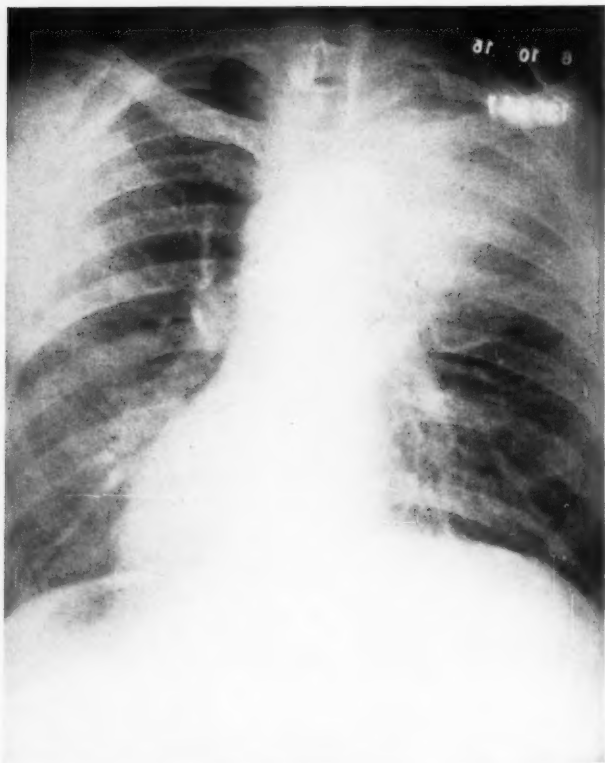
Case 130341. Actinomycosis. Clinical symptoms resembling tuberculosis. Sulphur bodies in sputum. Penetration of chest wall. x-Ray shadow: Fimbriated halo indicative of inflammatory conditions.
